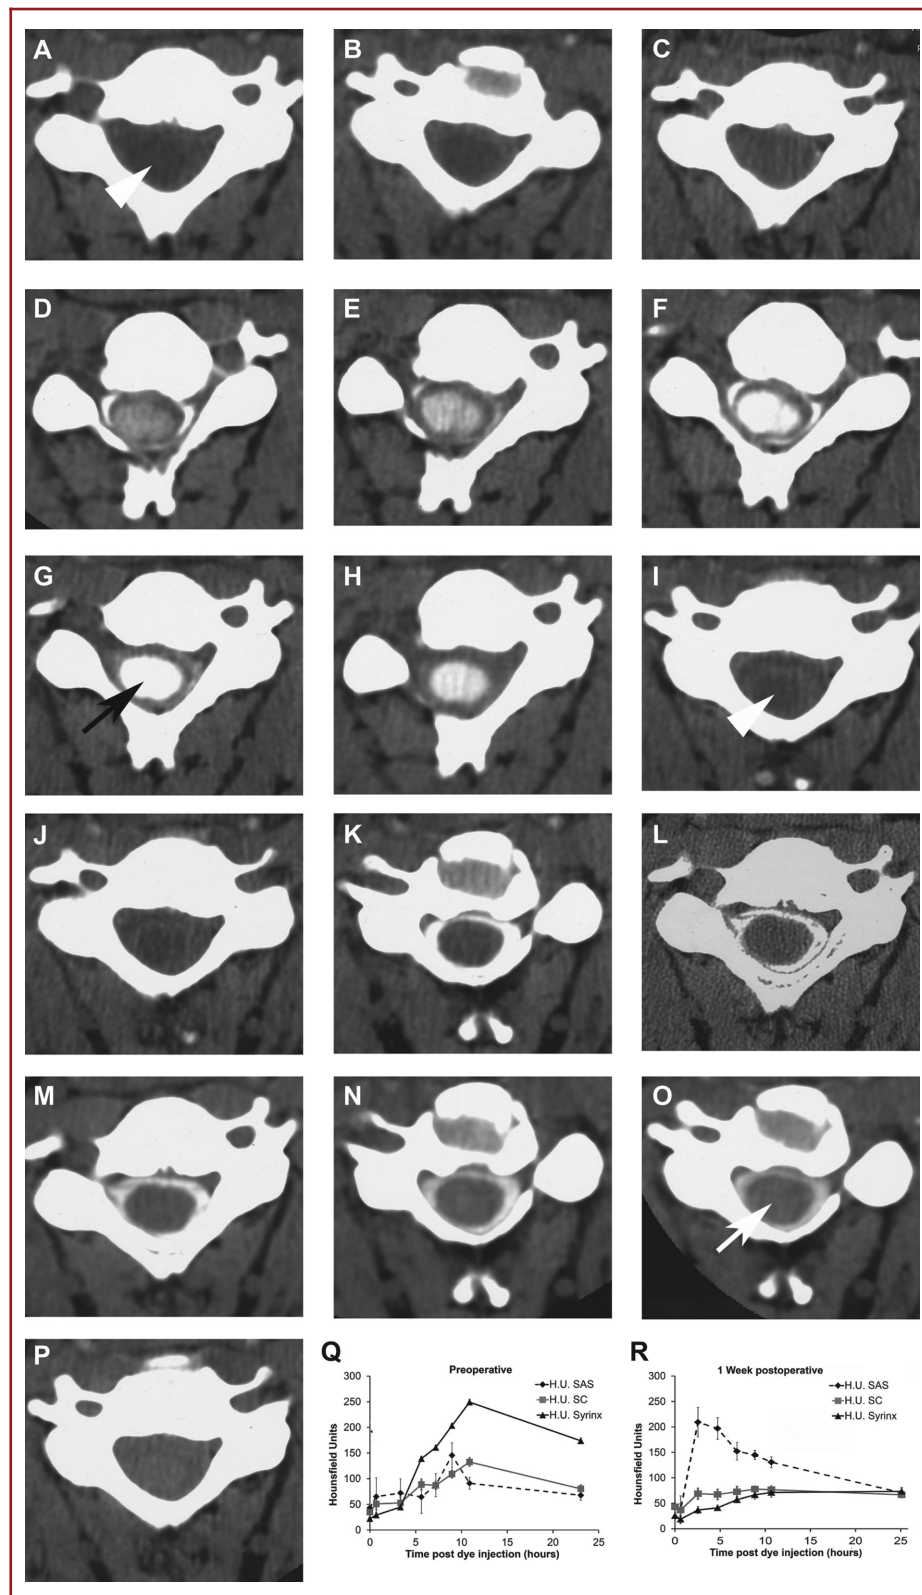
A-P, Serial CT axial images at the C6 spinal segment before A through H and after I through P thoracic laminectomy and duraplasty in a patient with a history of instrumented fusion of a traumatic fracture dislocation at the T8-9 spinal level years before and subsequent development of post-traumatic syringomyelia (Sp-S). Images A and I were obtained without contrast and the other images were obtained at these intervals (hours) after intrathecal contrast administration (CT myelography), 0.6 B, J, 3 C, K, 5 D, L, 7 E, M, 9 F, N, 11 G, O, 23 H, P h. The white arrowheads A, I indicate the central syrinx. Myelogram dye enters the syrinx to a much great extent before surgery (black arrow, G compared to after surgery (white arrow, O. Q and R, Hounsfield units in this patient were measured in the subarachnoid space, spinal cord, and syrinx from the sequential CT axial images, and graphs were drawn of the mean and standard deviation of pixel values (error bars) in these regions of interest at each time point. The graphs confirm the visual impression that much more myelogram dye enters the syrinx before Q compared to after R surgery in syringomyelia associated with a spinal canal lesion (Sp-S).
